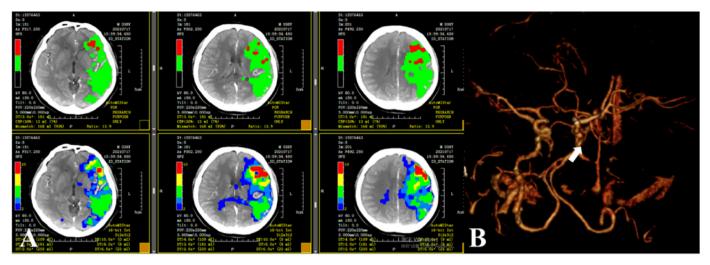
A: Left cerebral perfusion was impaired in CTP; B: Left-side ICA occlusion (white arrow) in cervical computed tomographic angiography.
